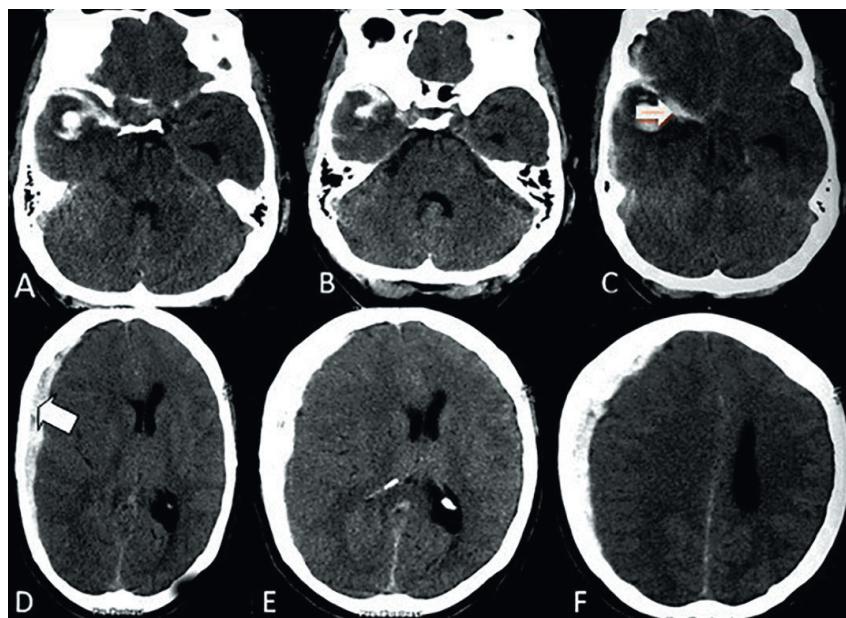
Non-contrast CT scan images of the patient with aneurysmal acute subdural haematoma. A, B, C: axial CT scan images showing blood in the left sylvian fissure with a small temporal haematoma (arrowhead). D, E, F: axial CT scan images showing left fronto-temporo-parietal acute subdural haematoma (arrowhead) with mass effect and midline shift.
